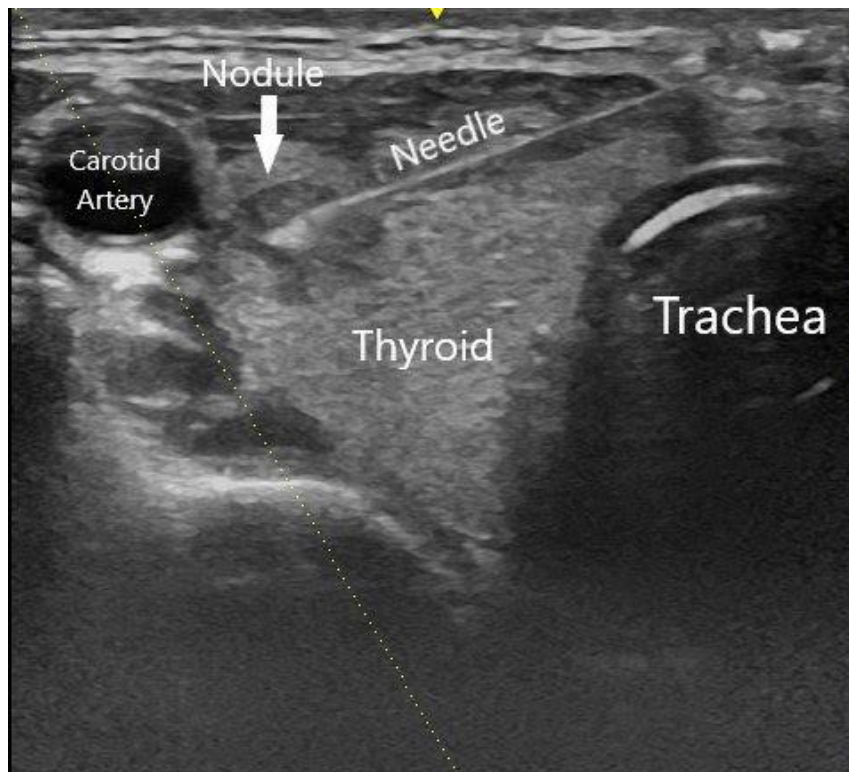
Image of an ultrasound-guided FNA. Available on <https://www.entandallergy.com/blog-posts/details/head-and-neck-fine-needle-aspiration-biopsy> (accessed on 24 October 2023)
